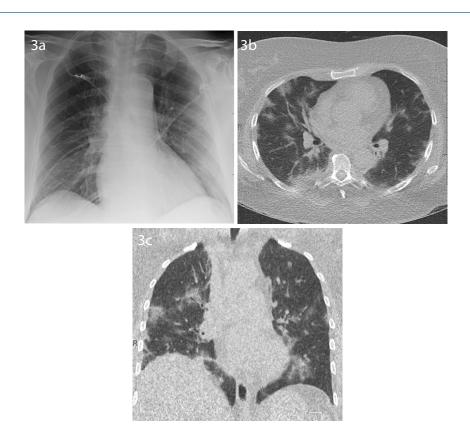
(A) Suboptimal, apparently unremarkable chest radiograph. (B and C) Patchy bilateral areas of ground glass on ultra-uldCT.
